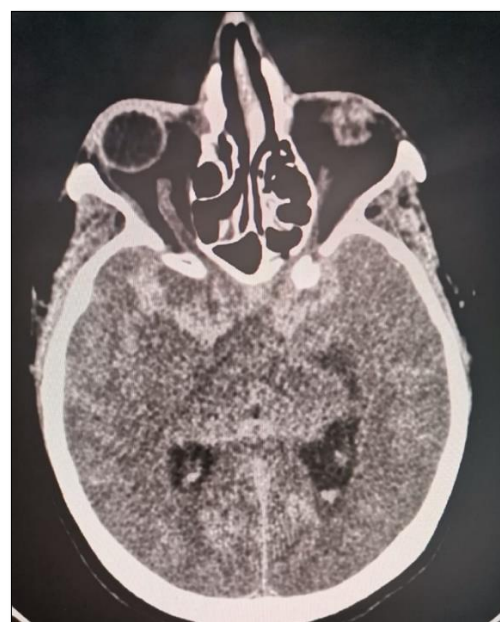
Cerebral computed tomography with angiography showing SAH with cerebral artery aneurysm.
